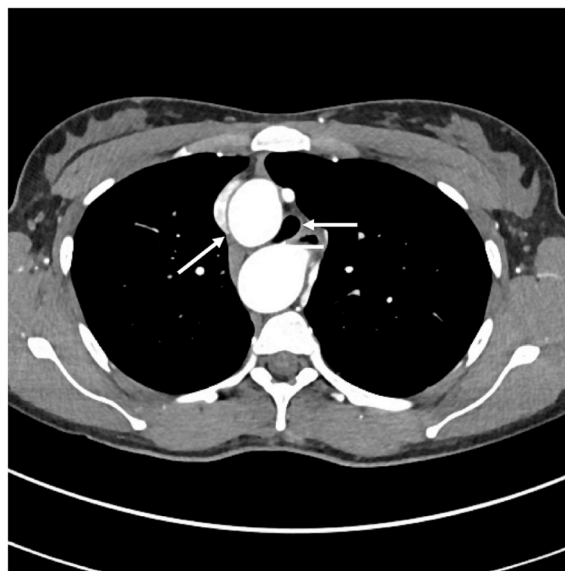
CT thorax with contrast demonstrating tracheal compression by vascular structures (short arrow indicating tracheal lumen; long arrow indicating right sided aortic arch at level T4; axial view).
